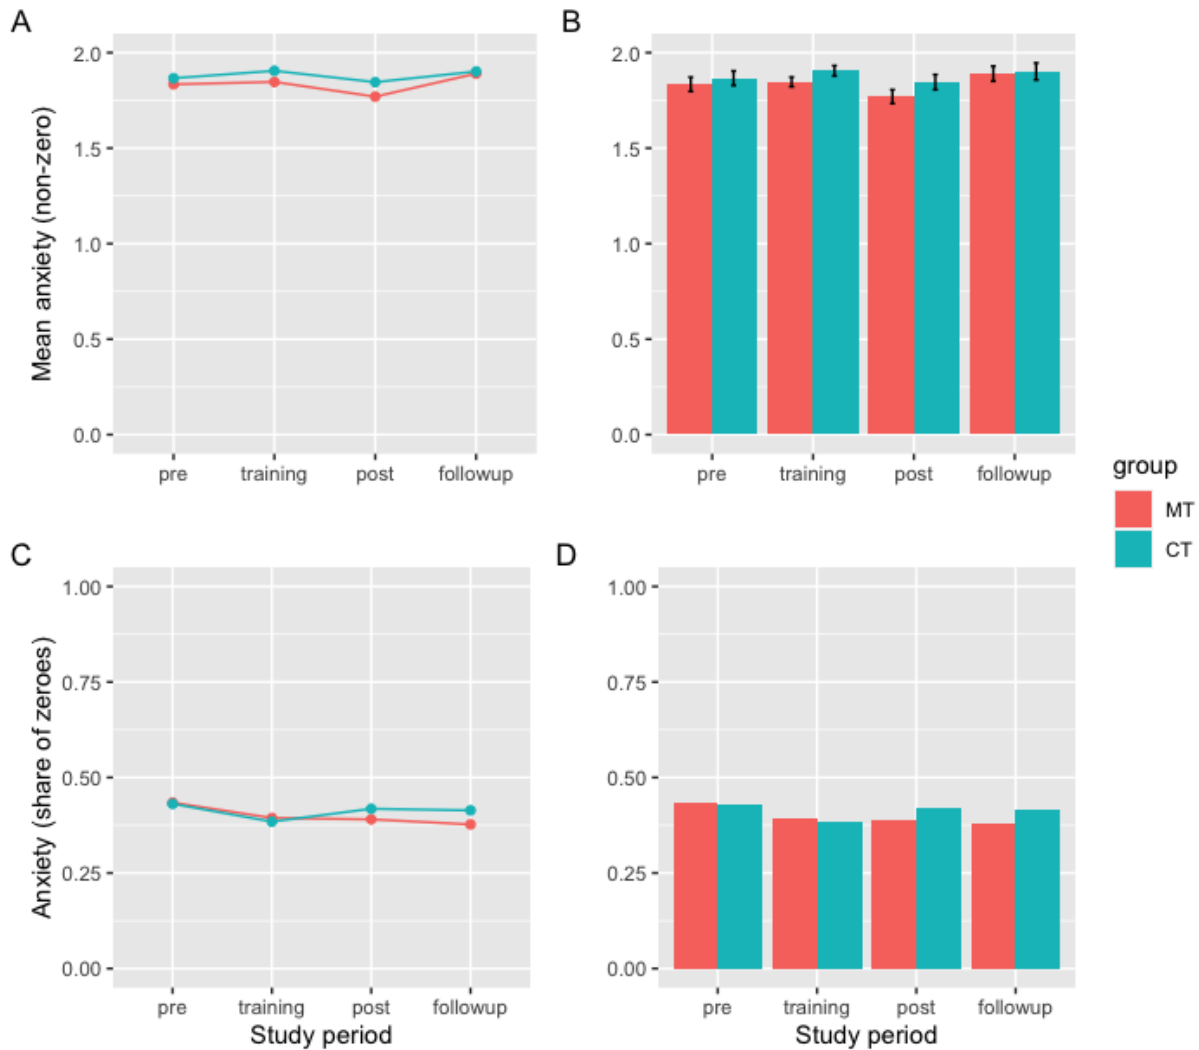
Average non-zero (A, B) and the share of zero anxiety scores (C, D) across the study; MT = mindfulness training; CT = control training
